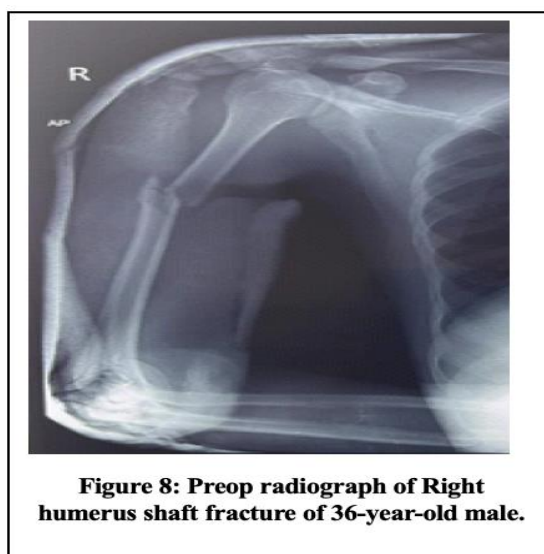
Preop radiograph of Right humerus shaft fracture of 36-year-old male.
